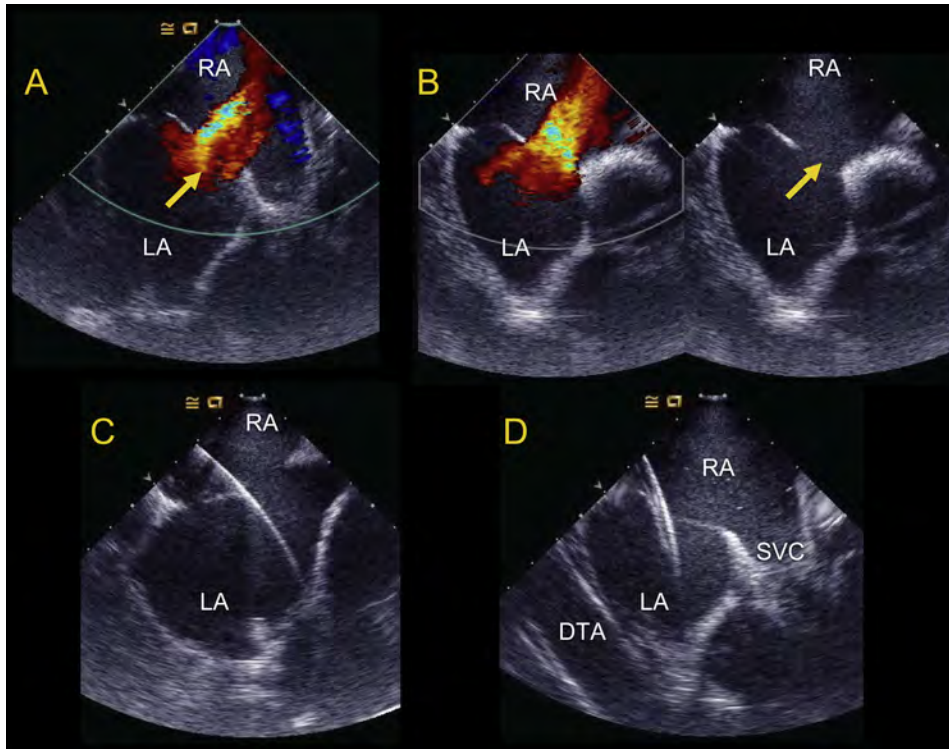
Intracardiac echocardiographically guided ASD closure of ostium secundum defect. (A and B) Preprocedure images demonstrating ostium secundum ASD. *Yellow arrow* indicates ASD. (C) Passage of guidewire into left superior pulmonary vein. (D) Passage of guide catheter into LA. DTA, descending thoracic aorta. See also [Videos 22 and 23](#).
